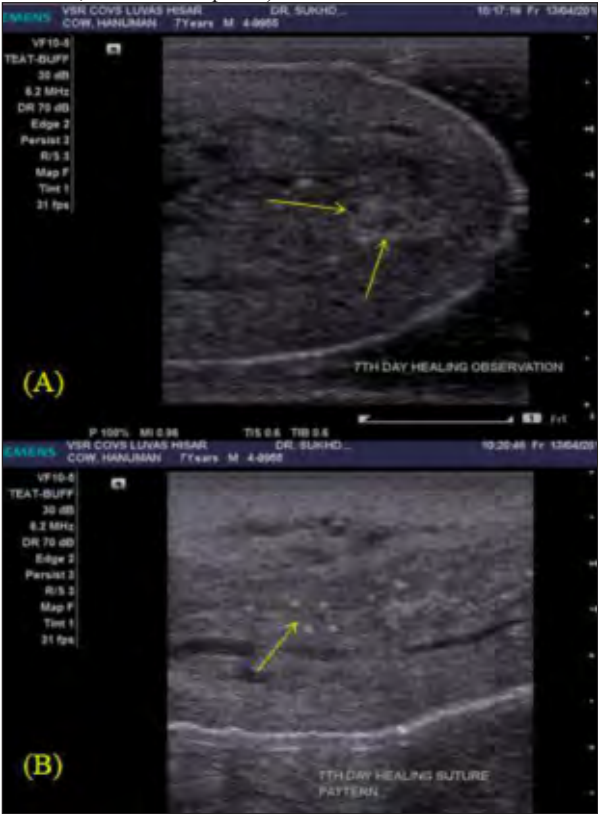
(A, B). Ultrasonographic image of teat fistula on seventh day observation show hypoechoic pattern at healing area marked by arrow (water bath technique; vertical scan; 6.2 MHz linear probe) group A
